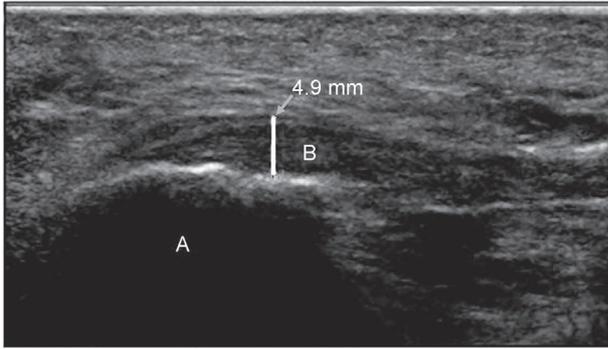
Longitudinal ultrasound image of the calcaneus (A) and the thickened plantar fascia (B).
